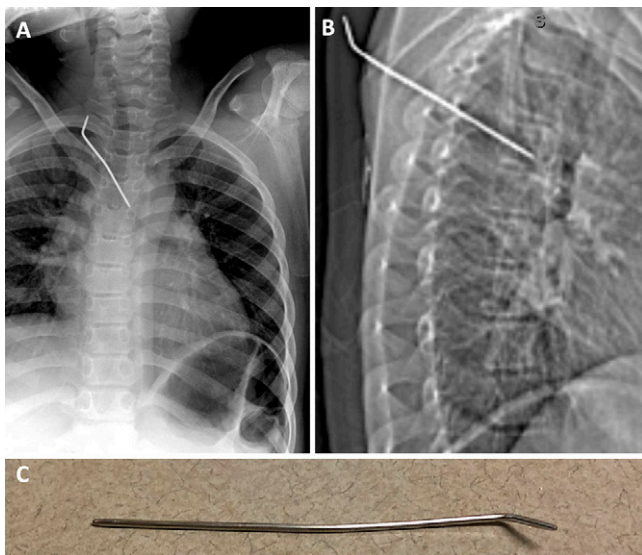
Anteroposterior (A) and lateral (B) radiographs showing the metal rod foreign body in the right upper thoracic paraspinal region angling from right to left, superior to inferior, into the left inferior part of the T4 vertebral body. Close-up image (C) of the foreign body after removal, an 11 cm × 2 mm diameter thin metal rod.
